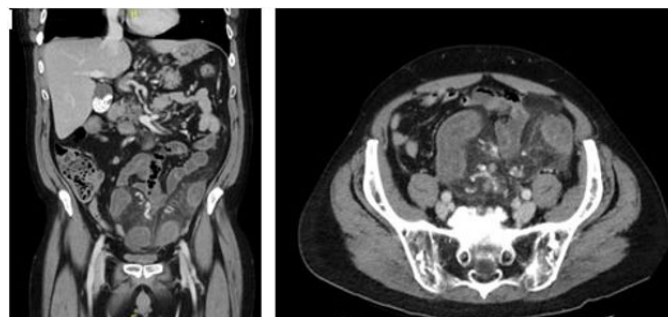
CT abdomen demonstrating colitis from splenic flexure to rectum.
